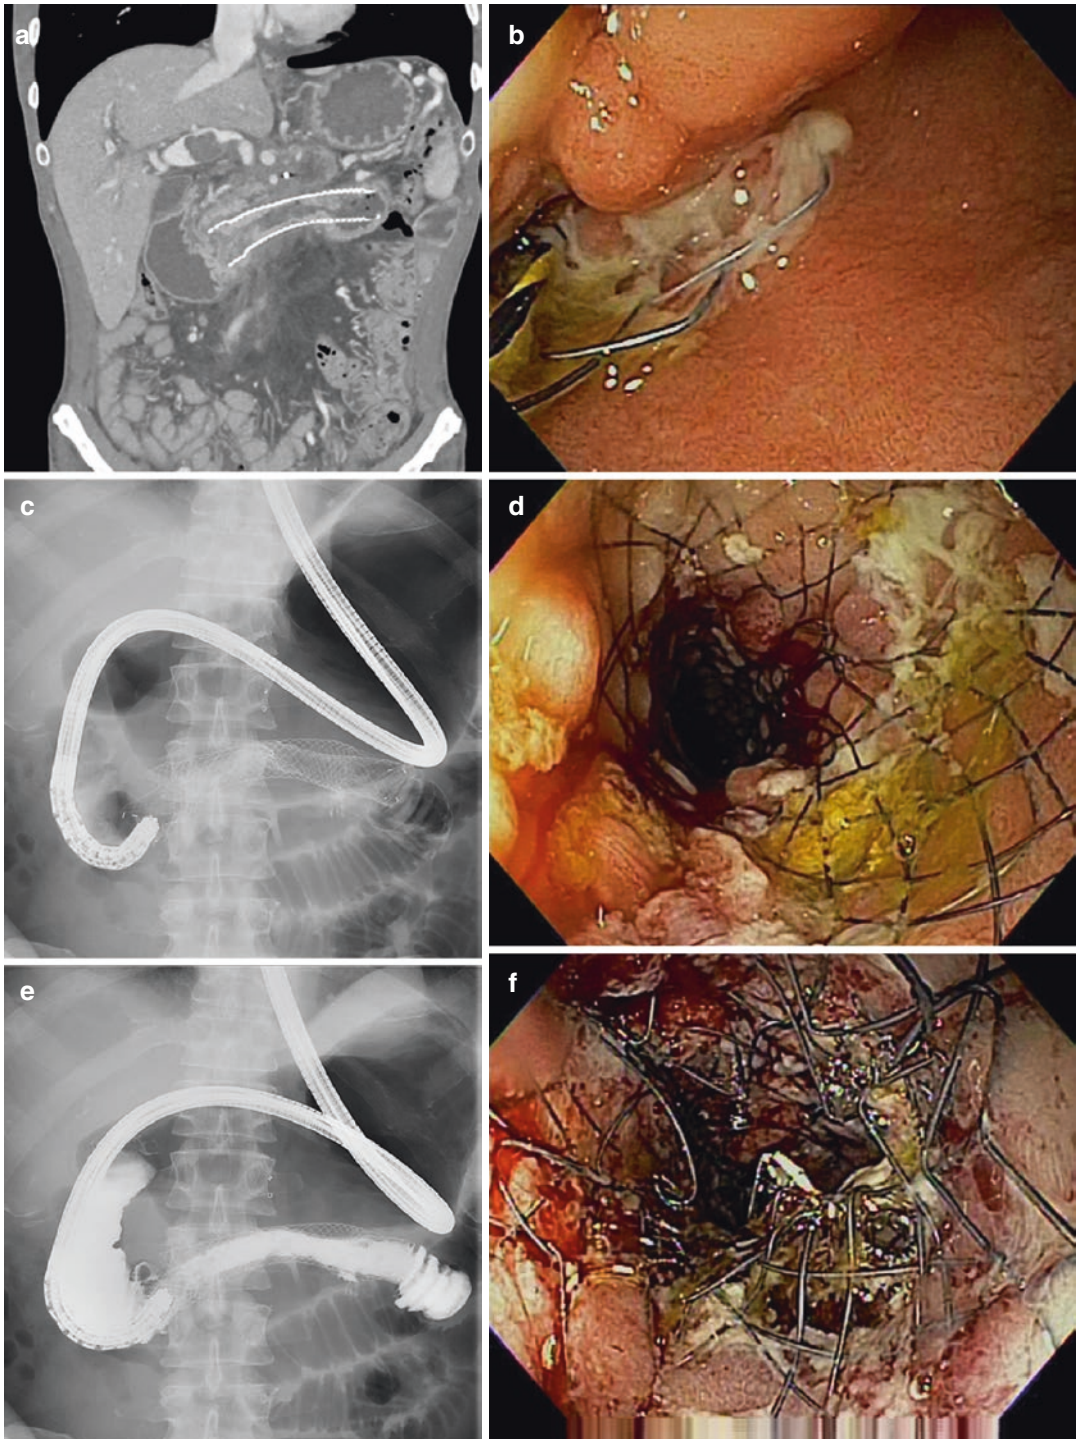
Management of enteral stent malfunction due to tissue ingrowth. (a) Radiographic appearance of existing enteral stent with visible tissue ingrowth in a patient with pancreatic malignancy. (b) Endoscopic view of malfunctioned existing enteral stent with severe tissue
